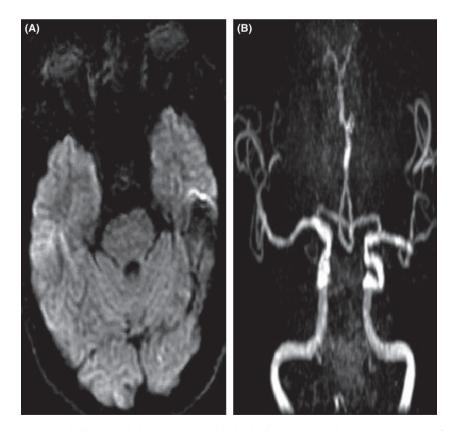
(A) No lesions on DWI before thrombolysis, DWI, axial. (B) The basilar artery was disappeared on MRA before thrombolysis, MRA, coronal.
